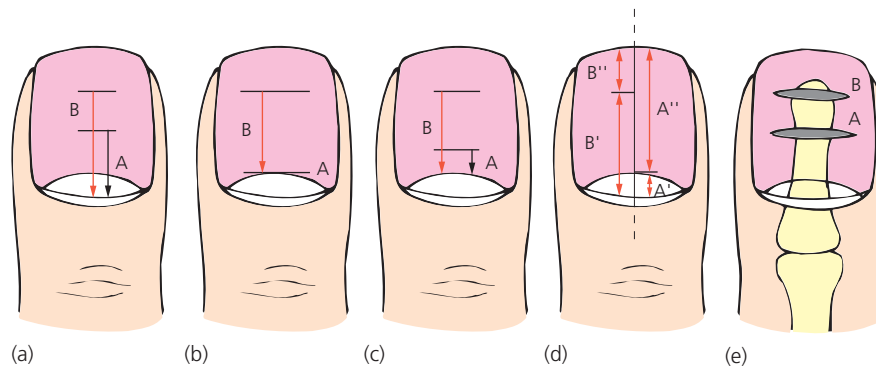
Methods of nail growth measurement. (a) Reference point, cuticle. Growth = $B - A$. Reproduced from Dawber [233] with permission from Wiley-Blackwell. (b) Reference point, lunula. Growth = $B - A$. Reproduced from Hillman [232] with permission from Wayne State University Press. (c) Reference point, lunula. Growth = $B - A$. Reproduced from Gilchrist [231] with permission from Wiley-Blackwell. (d) Reference point, cuticle and nail attachment margin distally. Growth = $(B' - A') + (A'' - B'')$. (e) Reference point, bone. Seen on x-ray with bismuth amalgam in transverse scratch in nail. Growth measured as movement of scratch from A to B and change in relation to radiological reference points on underlying bone.
